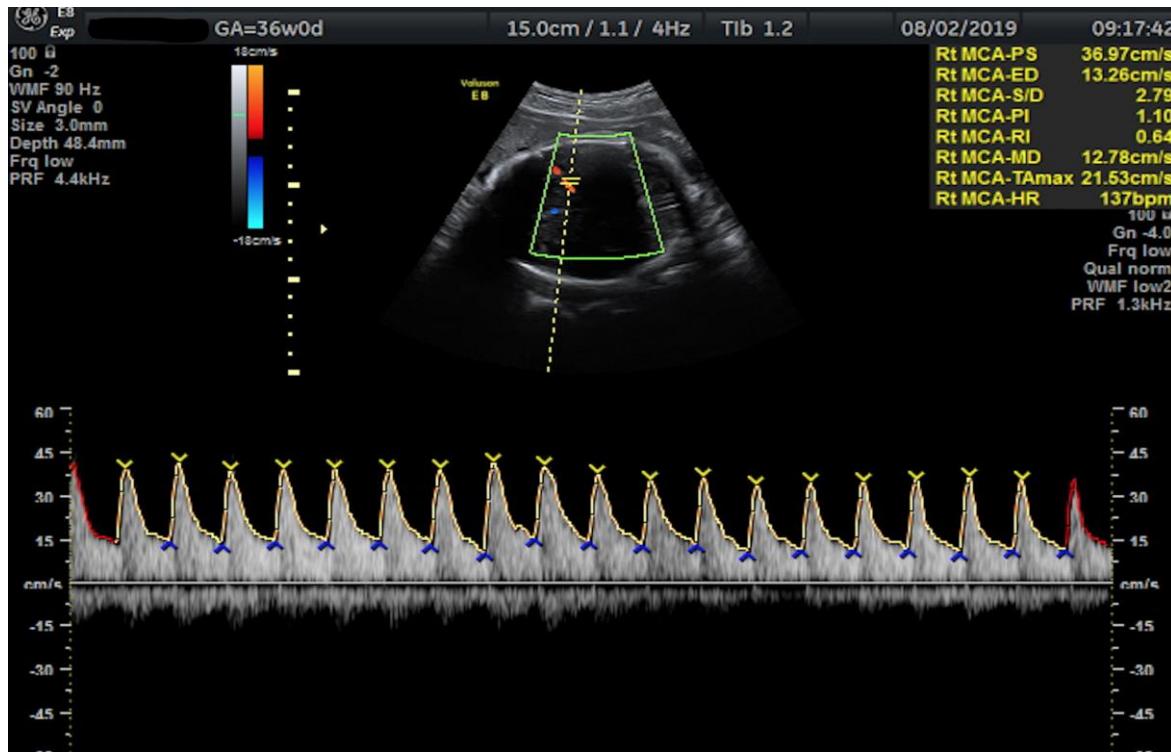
Doppler examination demonstrates the technique of the measurement of the blood flow of the middle cerebral artery. The measurement was taken at 36+0 weeks fetus with IUGR.
